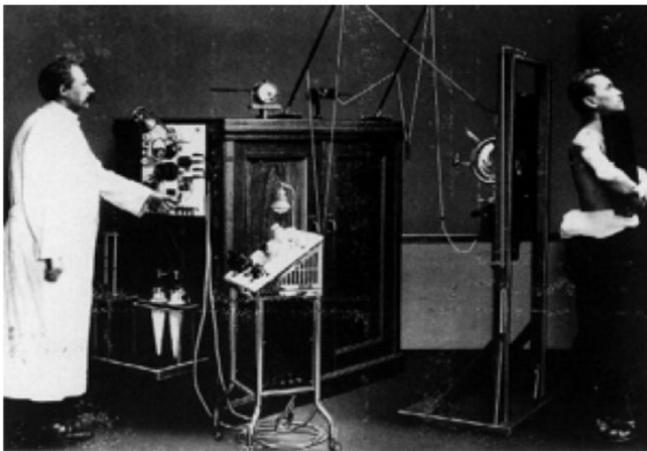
An X-ray system in the pioneering days where patients holding own cassette
